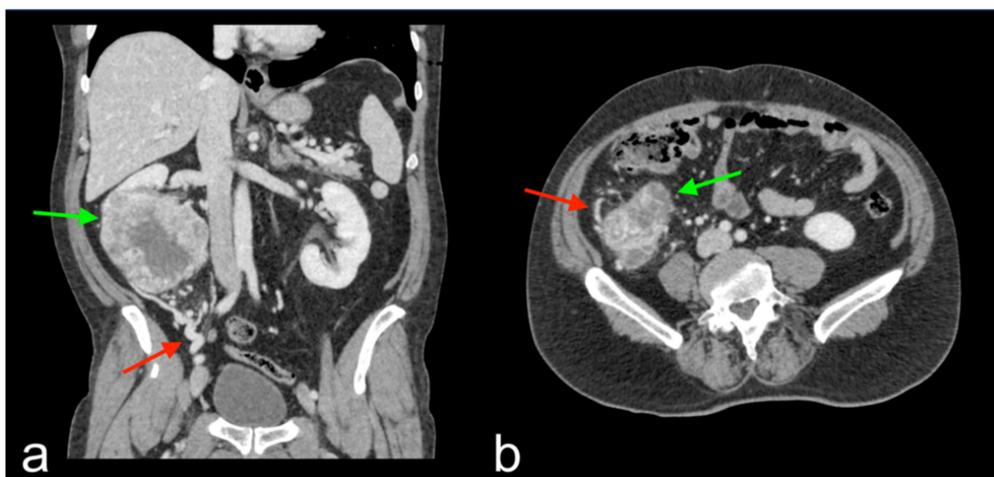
CT images in the coronal (a) and axial (b) planes of the abdomen in the venous phase, showing the presence of collateral vessels (red arrows) adjacent to clear cell renal cell carcinoma with a high Fuhrman grade (IV) (green arrow), with the characteristic tortuous course within the perinephric adipose tissue.
